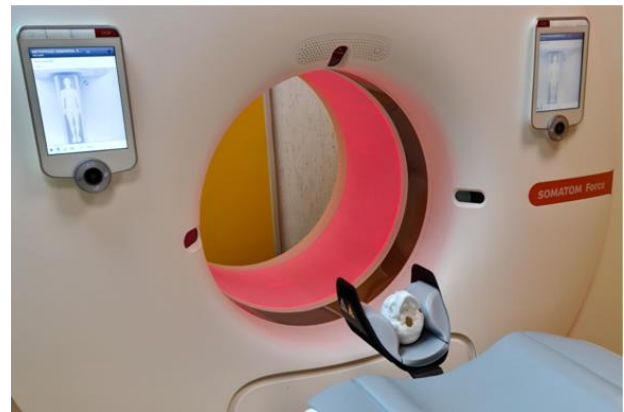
3DP cranial model CT scan in a dedicated stand.
